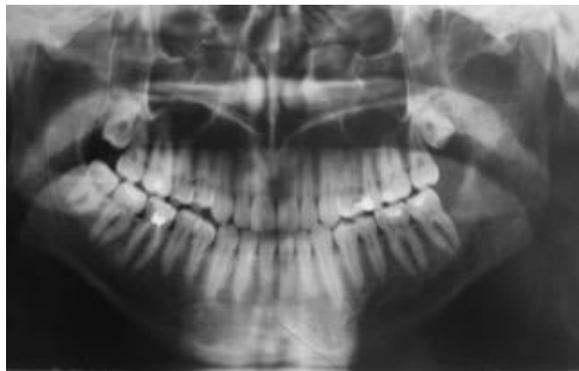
Orthopantomogram of patient N., AVM cavities are revealed in body and ramus of lower jaw
